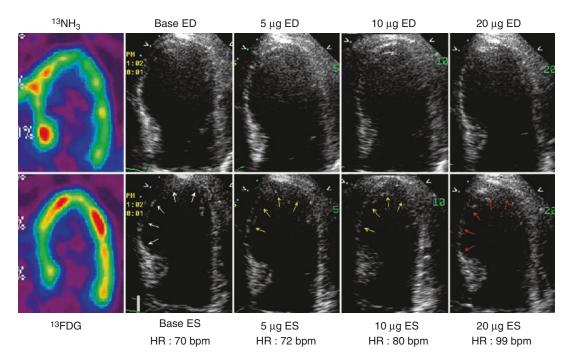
Inotropic response to dobutamine in dysfunctional segments (white arrows) with normal rest flow (¹³NH₃) and FDG uptake (¹⁸FDG). The upper row shows images obtained from the apical 4-chamber view in end-diastole at baseline and during the infusion of 5, 10 and 20 μg kg⁻¹ min⁻¹ of dobutamine. The lower row shows the corresponding end-systolic
